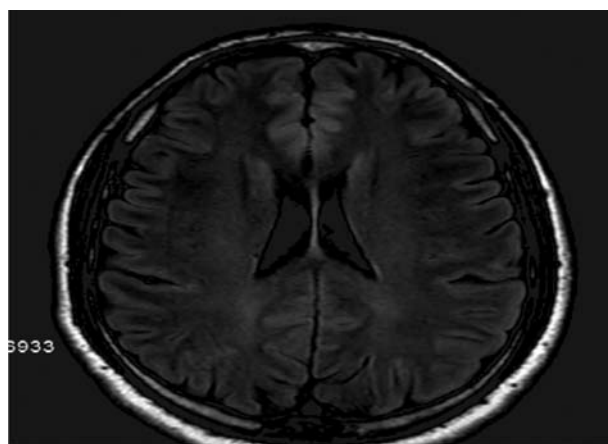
Normal Brain MRI.
